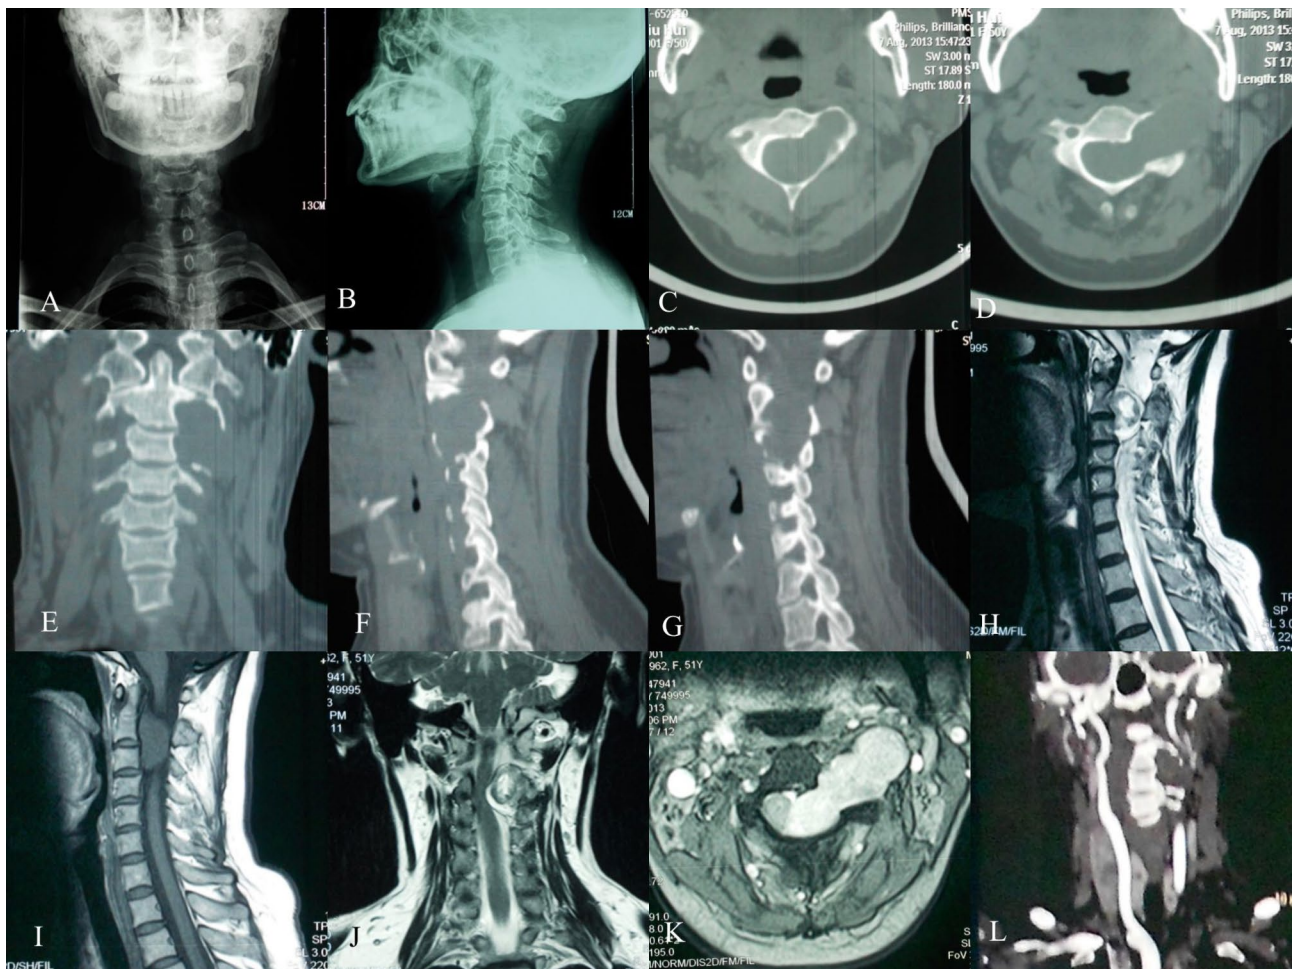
Preoperative imaging examination: A-B preoperative cervical anterior and lateral X-ray films; C-G preoperative CT showed that space occupying in spinal canal and left anterior bone destruction could be seen at cervical 2 level; The sagittal plane of MRI before H-K showed that space occupying in spinal canal could be seen at cervical 2–3 level, and it was dumbbell-shaped in cross section; L Preoperative CTA showed that the left vertebral artery was obviously compressed by tumor
